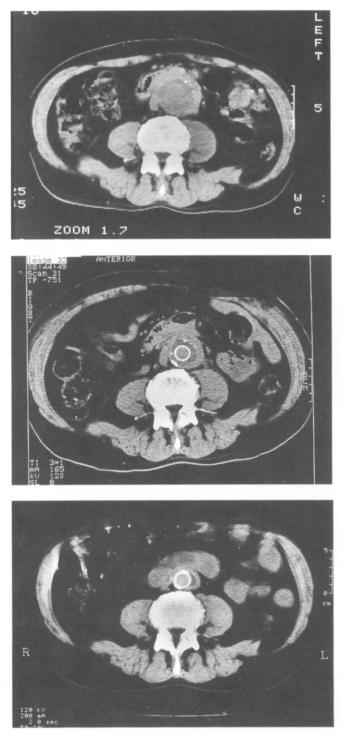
(a) Male, 64 years. Preoperative CT scan showing a 1 cm thick perianeurysmal layer of fibrotic tissue, surrounding a 4 cm AAA. Note calcified media central to the fibrotic mass. (b) Same patient. Three months after implantation of vascular prosthesis, slight reduction of the fibrosis is seen. (c) Same patient, 15 months after surgery. Partial regression of the perianeurysmal fibrosis.
